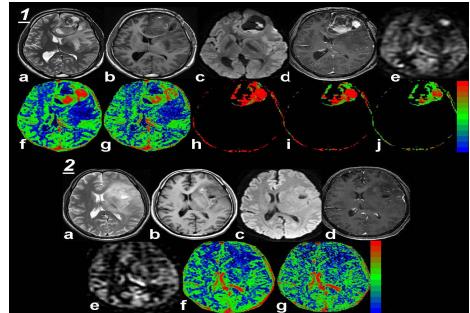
(a-d) conventional MRI of a high grade glioma (e) On ASL only a small region of the tumor is showing hyperperfusion, whereas on DCE derived (f)CBF (g)CBVcorr(h)  $k^{trans}$  & (j)  $v_e$  high values in the cellular regions of the tumor is evident. 2.(a-d) conventional MRI of a low grade glioma (e) On ASL almost entire tumor is showing hyperperfusion, whereas on DCE derived (f)CBF & (g)CBVcorr maps do not show any significant increase in the tumoral tissue. Due to absence of blood brain barrier disruption,  $k_{ep}$ ,  $k^{trans}$ , &  $v_e$  did not show positive values (not shown)
